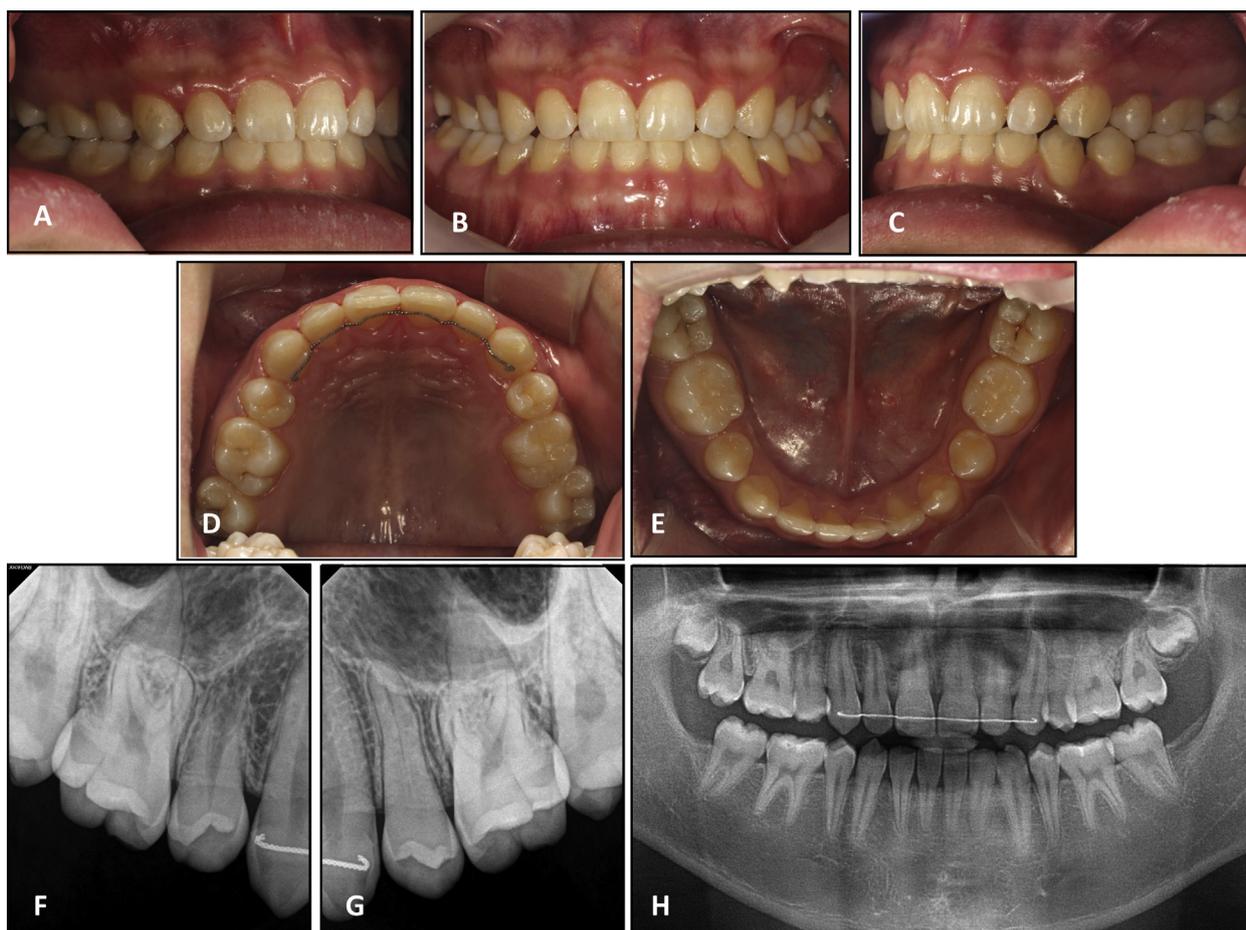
A-E, intraoral view, F, G, dental standard radiographs, and H, panoramic radiograph 4 years after tooth transplantation (16 years 2 months of age).
